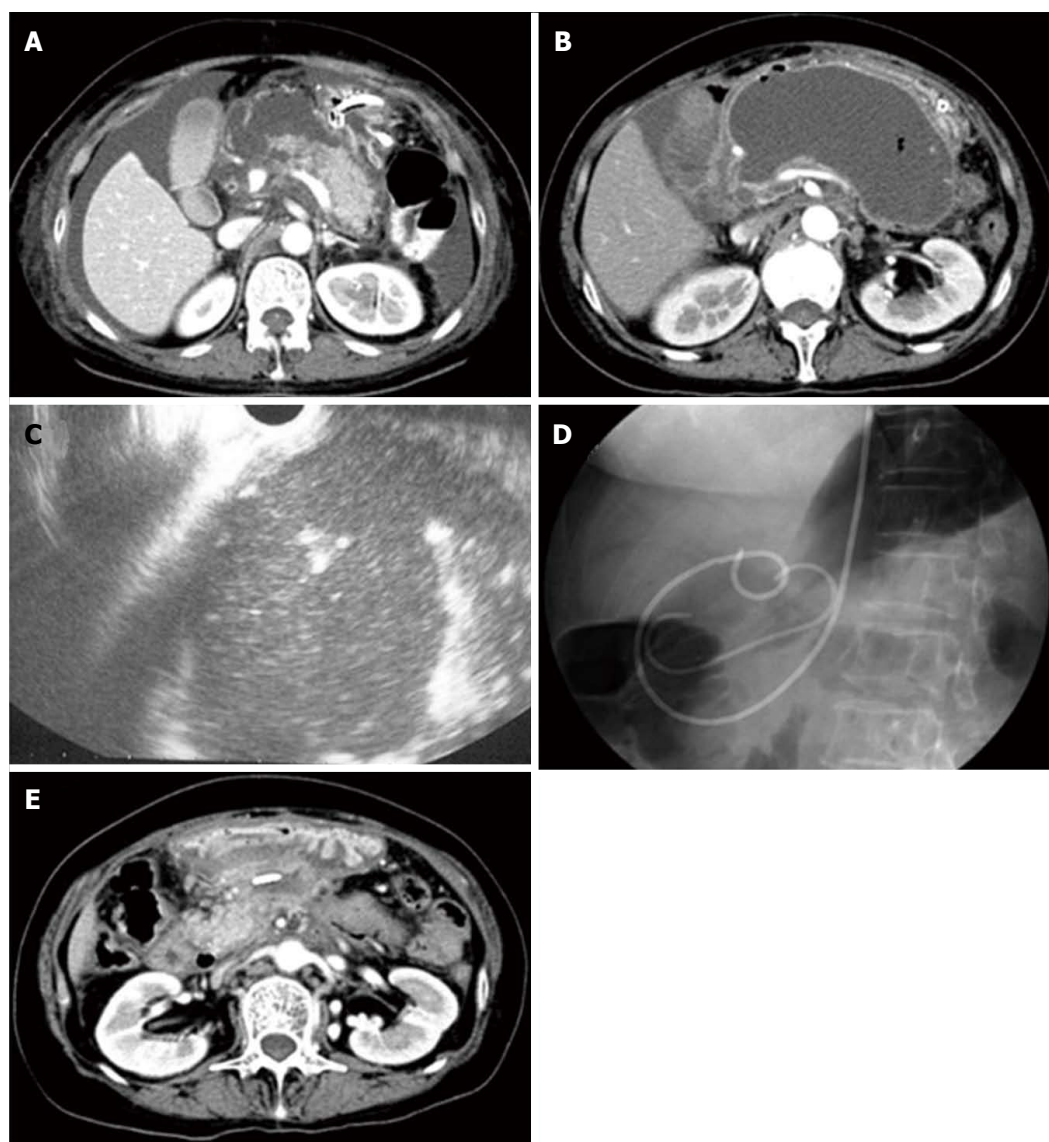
Representative case of walled-off necrosis resolved by endoscopic ultrasound-guided transmural drainage alone. A: Computed tomography of the abdomen (axial image) showing less than 50% pancreatic parenchymal necrosis; B: Pancreatic fluid collection was 135 mm in diameter; C: Rich debris seemed to exist in the cavity as shown by endoscopic ultrasound; D: Endoscopic ultrasound guided transmural drainage was performed and pancreatic fluid collection culture was positive; E: Cavity was reduced at 6 wk after intervention.
